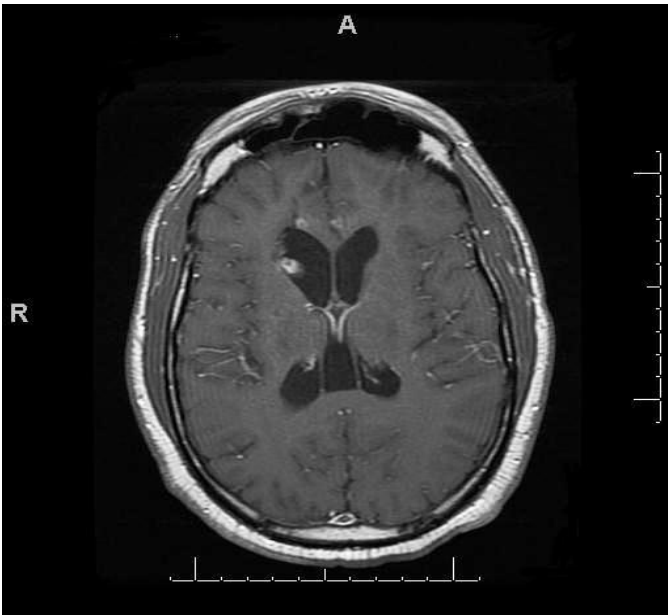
Brain MRI Post treatment with WBRT (T1 axial image post gadolinium) showing small foci of heterogeneous enhancement involving the right caudate nucleus and the right genu of the corpus callosum. In comparison to prior study, significant improvement is seen.
